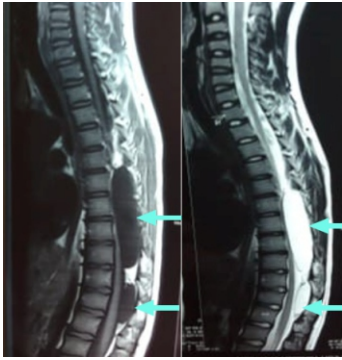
Sagittal Cuts On MRI: T1W and T2W showing two lobulated arachnoid cysts (arrows shows compression in spinal cord)
